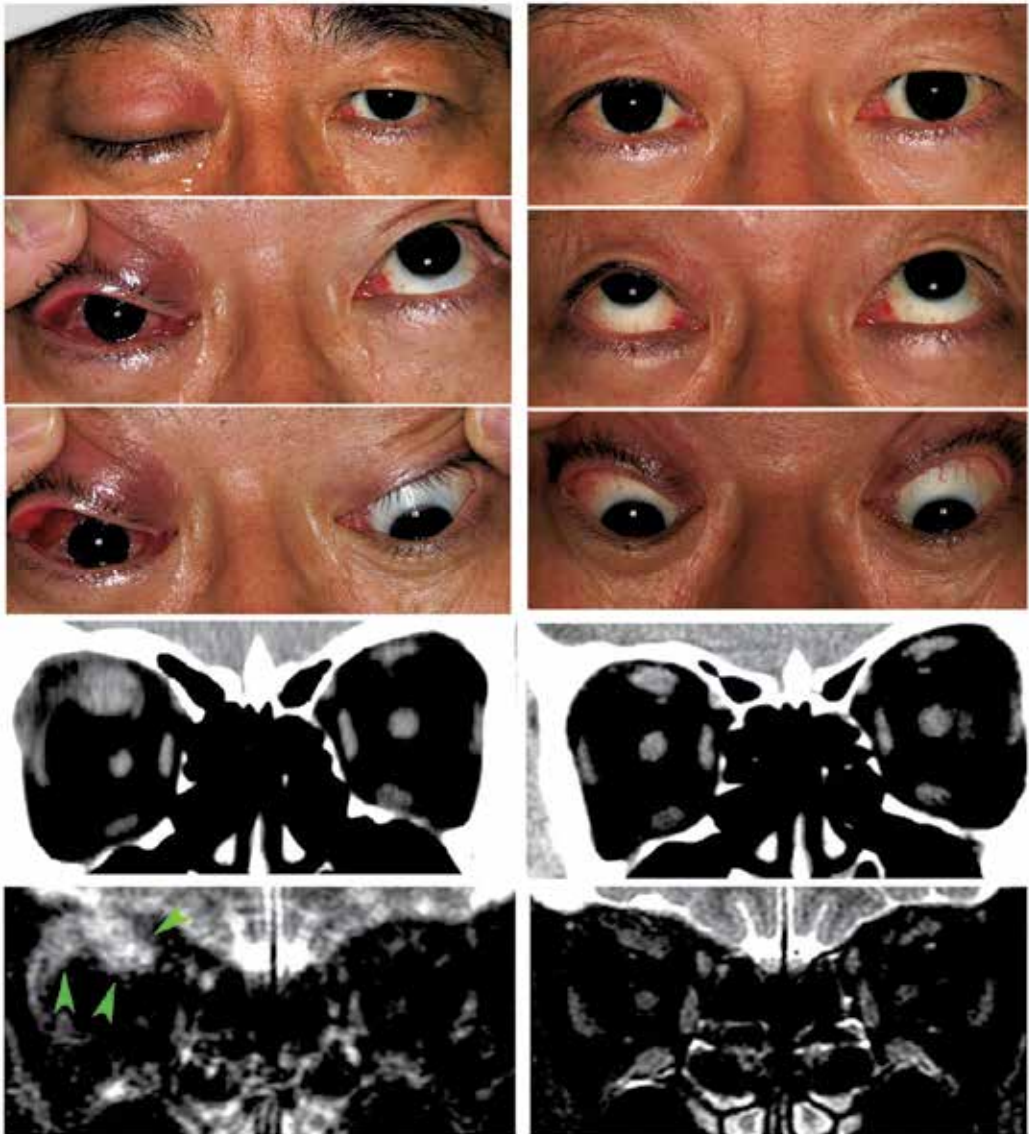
Acute type of idiopathic orbital myositis. Left: External photographs of a 58-year-old man showing swelling of the right eyelid, ptosis, and ocular motility restrictions in the field of action and in the direction opposite to the field of action of the affected extraocular muscles. Severe engorgement of the conjunctival and episcleral vessels overlying the right eye. Fat-suppressed T2-weighted MR image at the active phase shows a hyperintense signal around the fascicular structures (arrowhead). Right: Same patient after 1000 mg intravenous methylprednisolone for 3 days (steroid pulse therapy). There is a complete recovery from signs and symptoms. MR images are normal.
